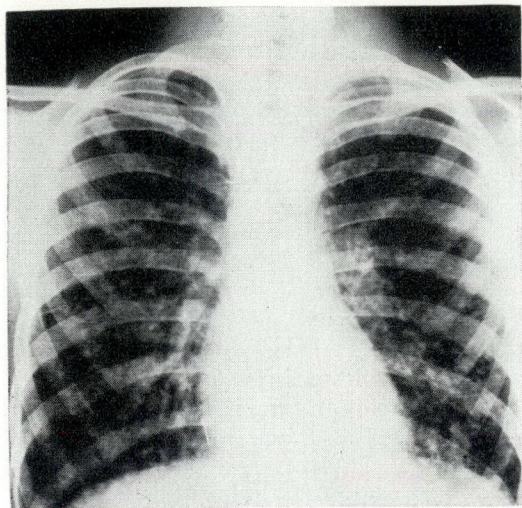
Radiographic appearance of Case 3 at the time of diagnosis, February 1956.
